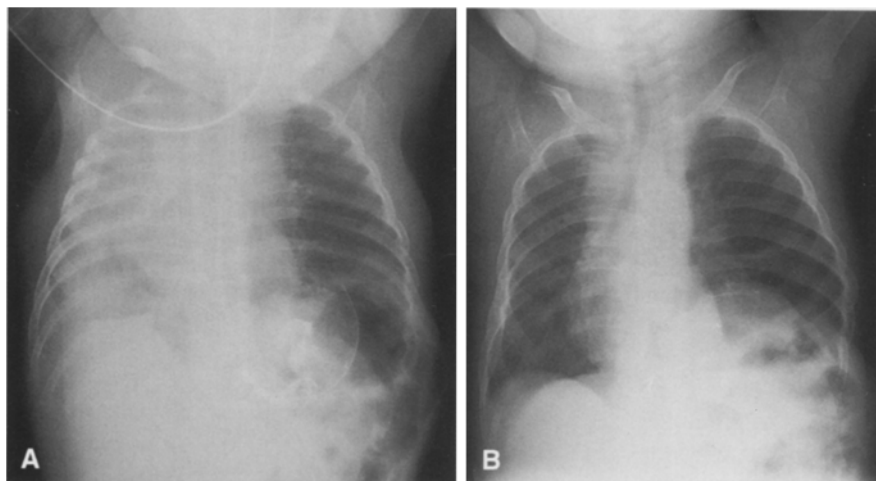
A Recurrent right-sided chylothorax in case 3 despite placement of multiple chest tubes. B Chest radiograph 5 months after pleurectomy and ligation of thoracic duct. Note absence of any effusion (breakdown of diaphragmatic hernia repair was subsequently reoperated)
